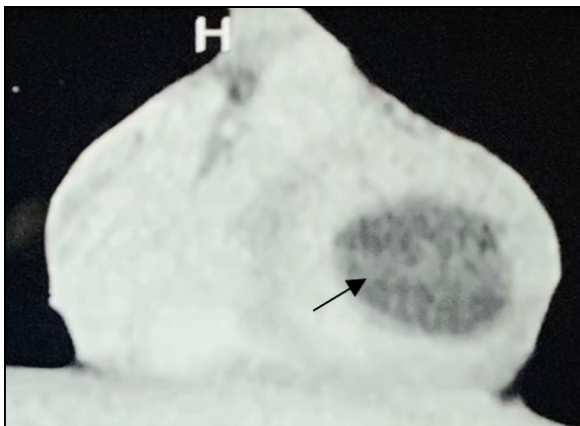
CT scan of chest (coronal section) shows left ventricle hydatid cyst.
